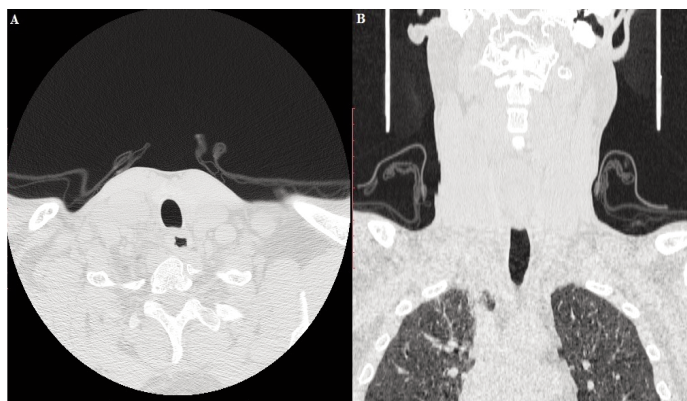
(A, B): Chest CT scan performed during inspiration shows no evidence of lung herniation. (A : axial view in parenchymal window, B: coronal view in parenchymal window)
